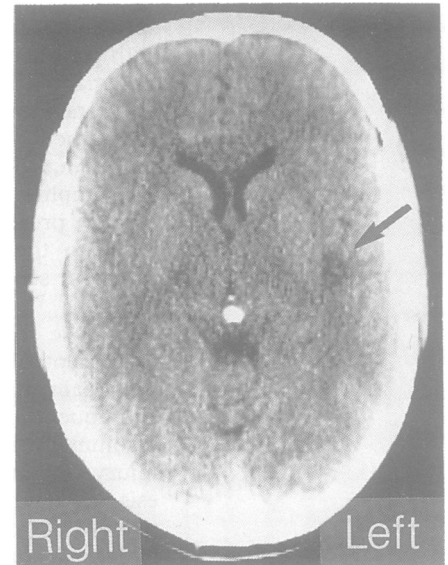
Figure CT scan showing a small left temporal lobe infarction. An arrow delineates the lesion.
